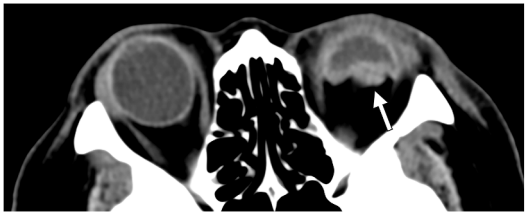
Axial CT orbits showing a left globe rupture with crenated appearance (*white arrow*).
